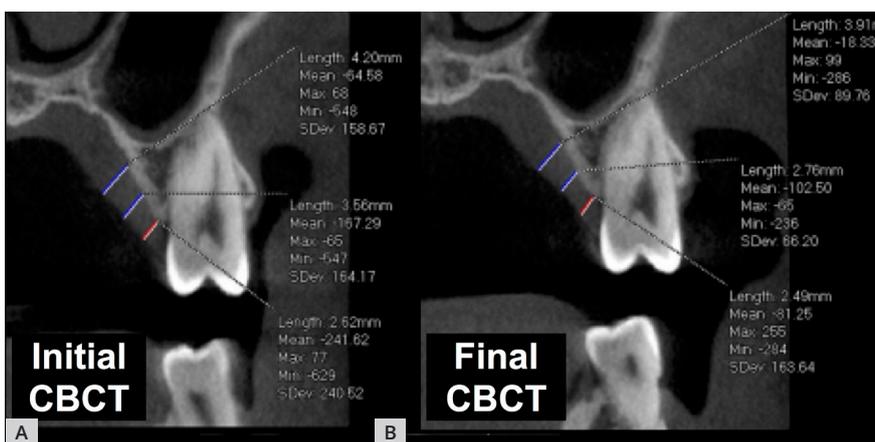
Measurement of palatal mucosa thickness at 3, 6 and 9 mm of the gingival margin using the overlapped CBCT images in the second premolar region after the overlapping performed with PreXion 3D Viewer software. A) Initial CBCT image, B) final CBCT image
